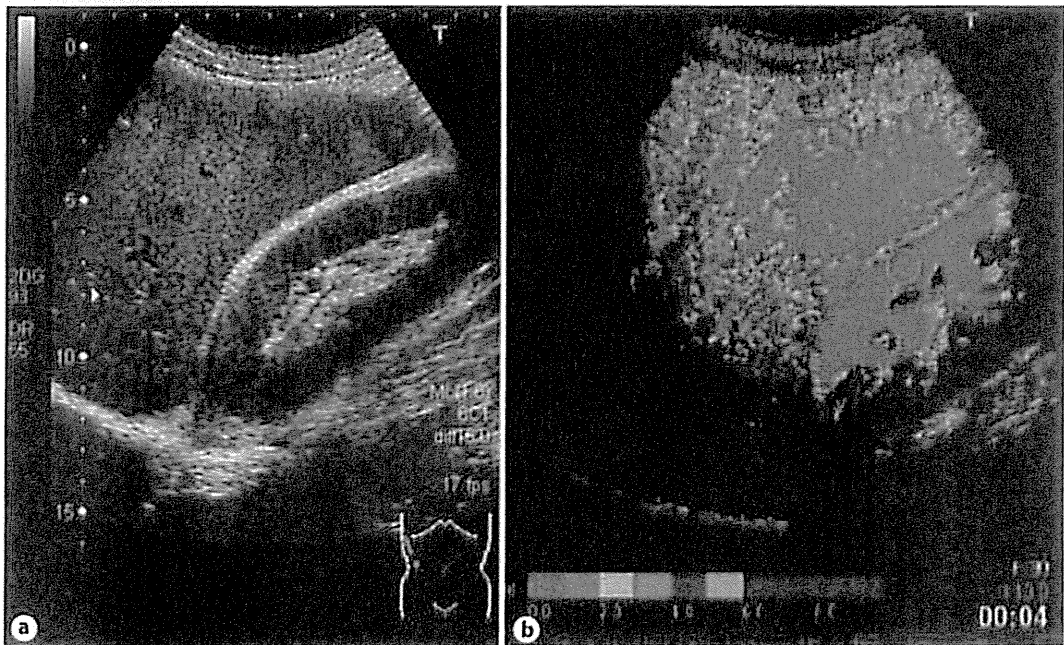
Ultrasound images of case 2 taken in July 2010. a B-mode ultrasound image. b Arrival time parametric image. The ratio of the red-colored region, indicative of early arrival, increased for a second time in the entire area of the arrival time parametric image of the liver.
